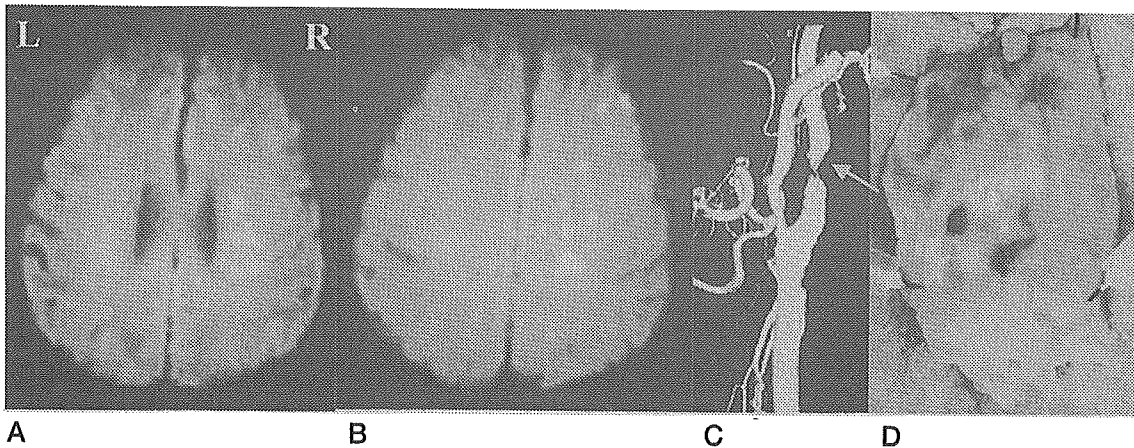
67歳 男性の入院時 stroke MRI
